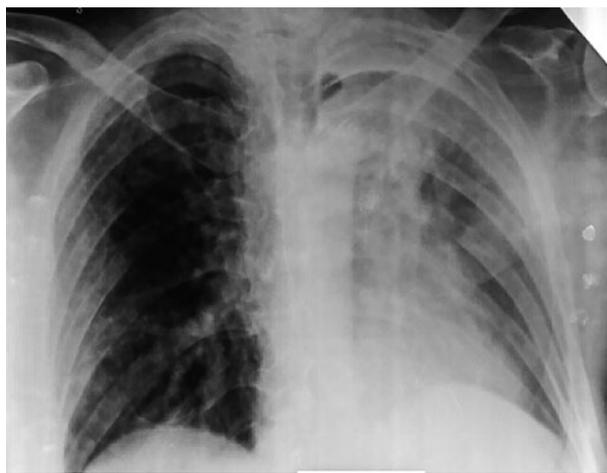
Chest X-ray dated 19 February 2024, taken in the infectious diseases hospital
